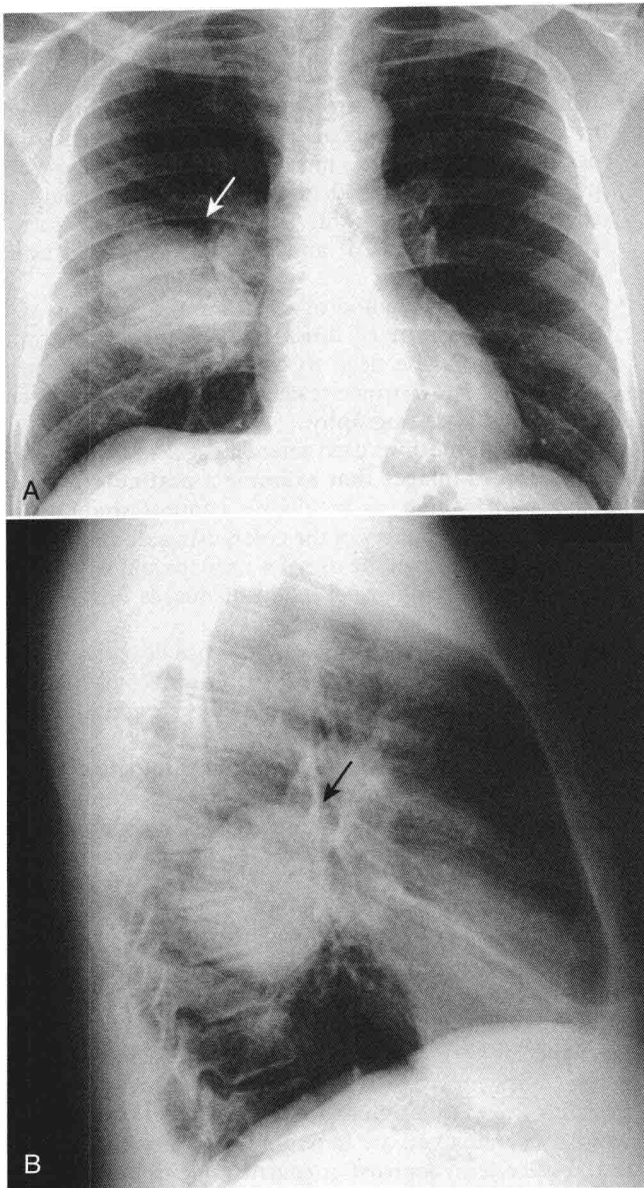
Right lower lobe bronchogenic carcinoma. A nearly spherical mass is in the right lower lobe of the lung seen on the frontal (A) (solid white arrow) and lateral (B) (solid black arrow) radiographs of this patient. Because the mass is nearly spherical, it has relatively the same shape when viewed *en face* and *in profile*.
